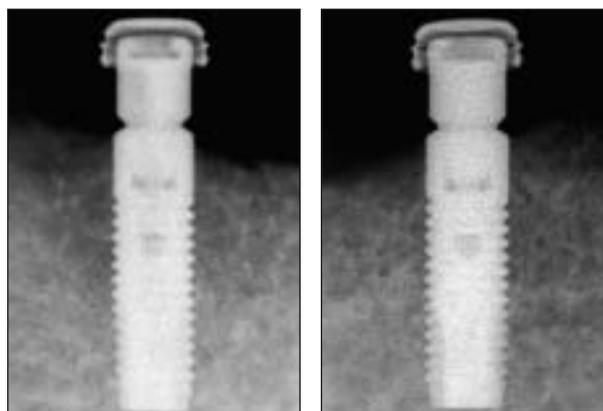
Standardized periapical radiographs at 3 years.
